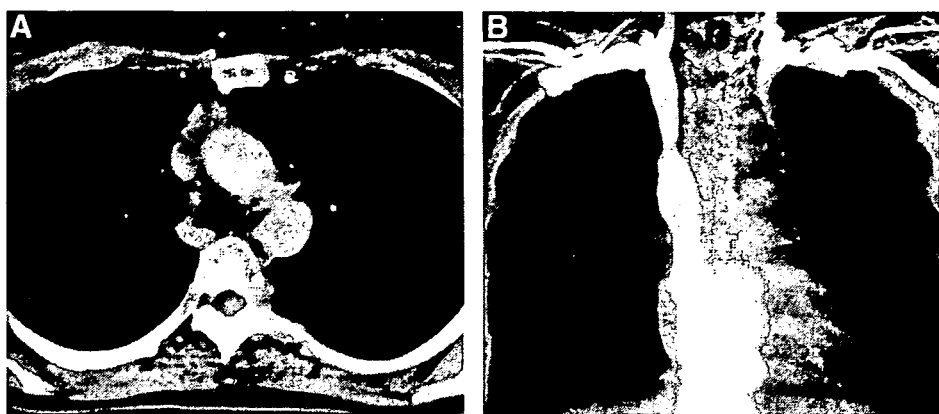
Patient 5 after four cycles of induction chemotherapy. (A) CT scan revealing considerable shrinkage of the tumor. (B) Venous phlebogram demonstrating the marked improvement of superior vena cava obstruction.
